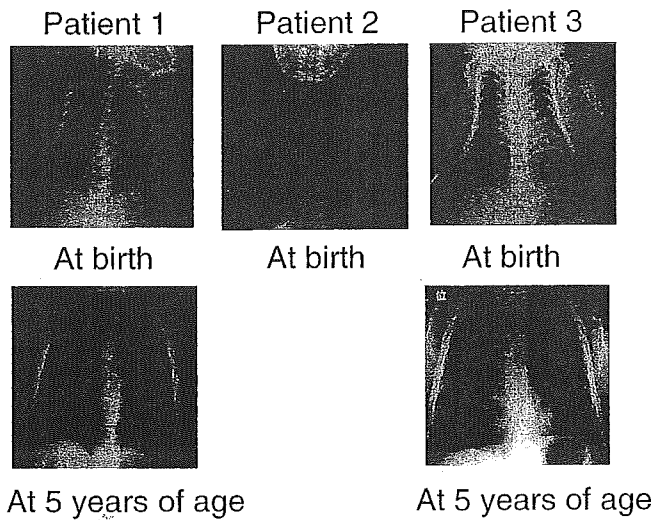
Roentgenograms of Patients 1–3. The unique bell-shaped thorax with an arched appearance of the ribs is obvious in Patients 1–3 at birth, and the thoracic deformity has ameliorated in Patients 1 and 3 at 5 years of age.
